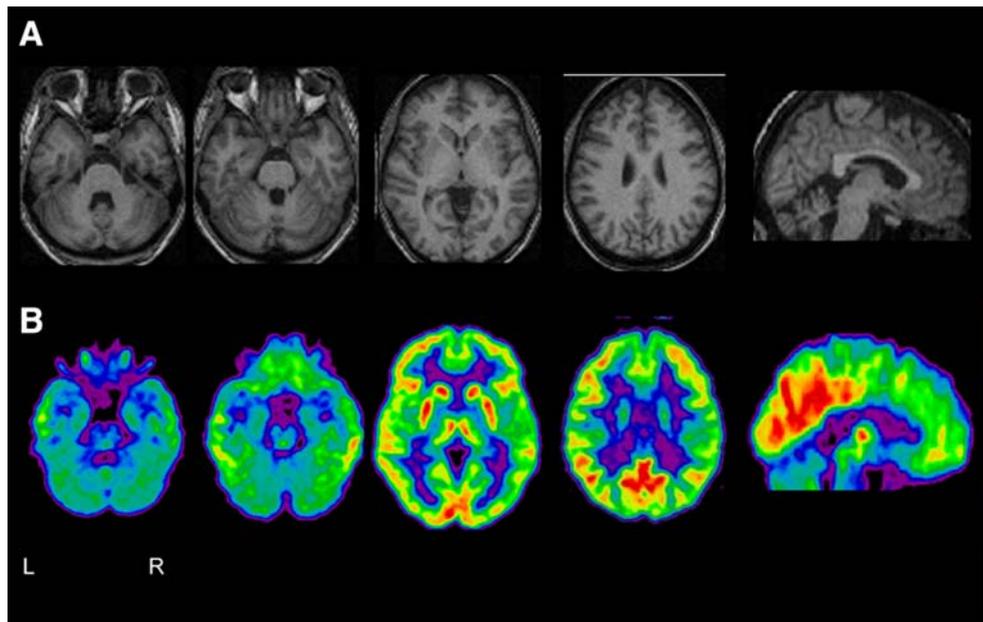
Axial and sagittal slices of MRI T1 weighted images (a) and [18F] FDG PET scans (b) in case 1. Images were normalised in the Montreal Neurological Institute space using SPM2 (Wellcome Department of Imaging Neuroscience, London, UK). MRI shows
